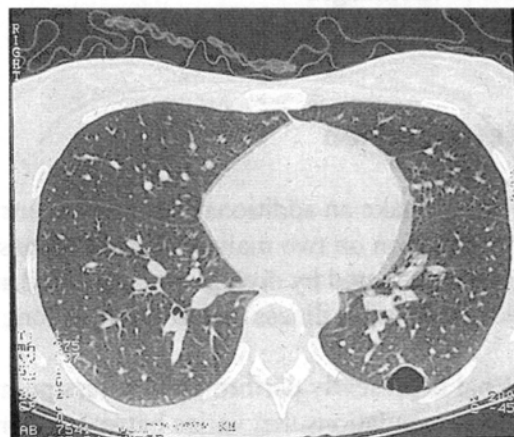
Chest CT of a 25 year old female sport diver (Case 1).
